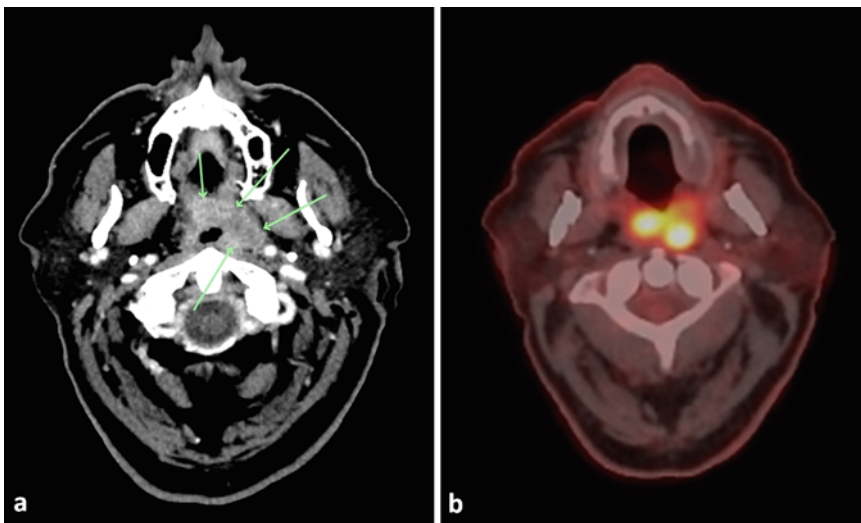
Squamous cell carcinoma of the palatine tonsil. CT (a) shows an expansile enhancing mass lesion centered in the left palatine tonsil. The lesion has an unusual morphology, and it involves the entire left palatine tonsil and extends superiorly to the junction of the upper oropharynx with the lower nasopharynx. Anteriorly at the upper pole region, it crosses the midline and involves the posterior aspect of the soft palate and the uvula, and further
